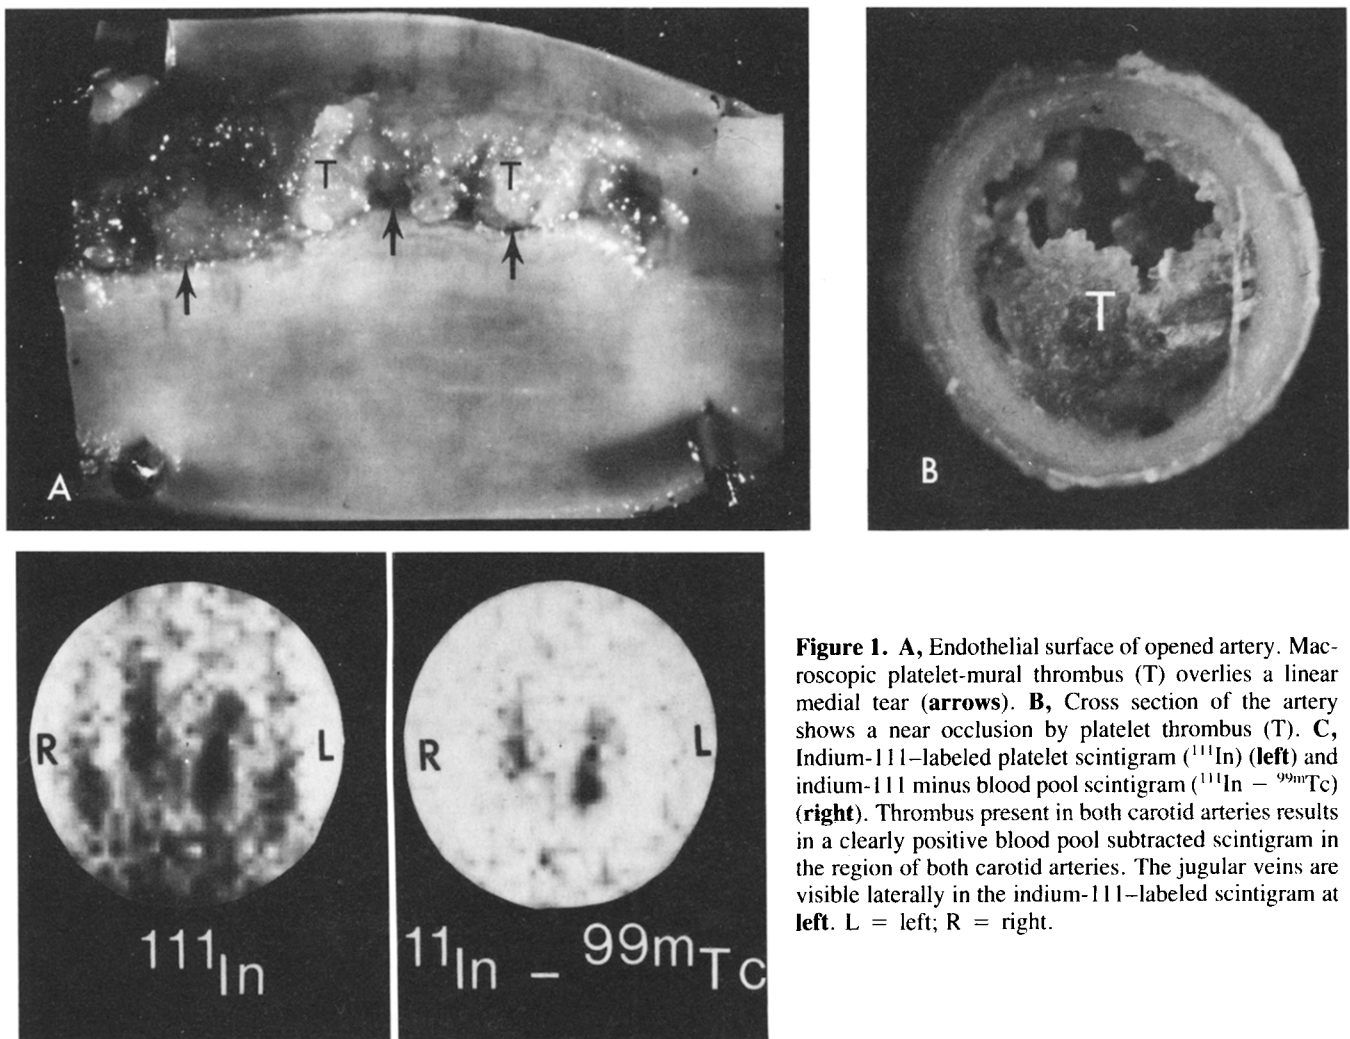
A, Endothelial surface of opened artery. Macroscopic platelet-mural thrombus (T) overlies a linear medial tear (arrows). B, Cross section of the artery shows a near occlusion by platelet thrombus (T). C, Indium-111-labeled platelet scintigram (^{111}In) (left) and indium-111 minus blood pool scintigram ($^{111}\text{In} - ^{99\text{m}}\text{Tc}$) (right). Thrombus present in both carotid arteries results in a clearly positive blood pool subtracted scintigram in the region of both carotid arteries. The jugular veins are visible laterally in the indium-111-labeled scintigram at left. L = left; R = right.
